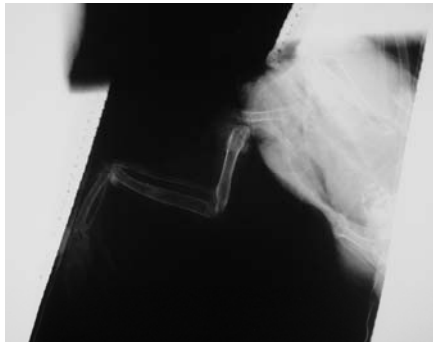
Lateral radiograph of the corrected wing, 3 months after surgery.
